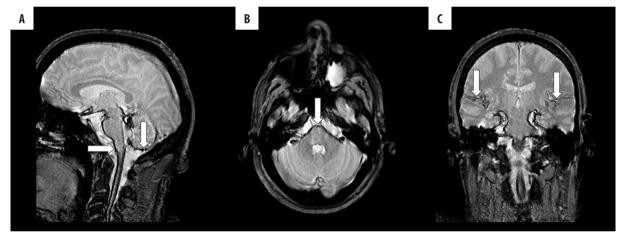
(A–C) MRI (T2*-GRE) showing bilateral hypointensity on the pial surface of the trunk, of the cerebellar sulci, and along the subarachnoid course of the main cranial nerves (arrows). This was attributed to hemosiderin deposition in the context of diffuse cortical involution
